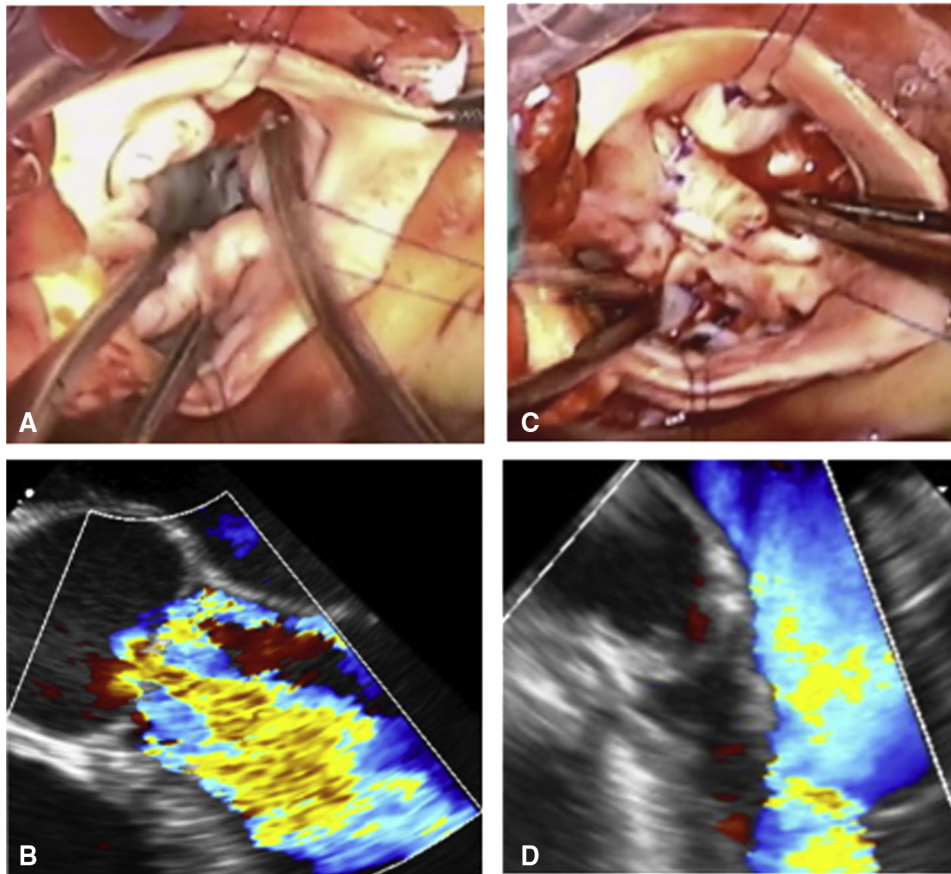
A, Prerepair appearance of type 1 bicuspid valve showing dysplastic incompetent leaflets. B, Prerepair echocardiogram showing severe aortic insufficiency. C, Postrepair valve appearance with good leaflet coaptation. D, Postrepair echocardiogram with a fully competent valve.
